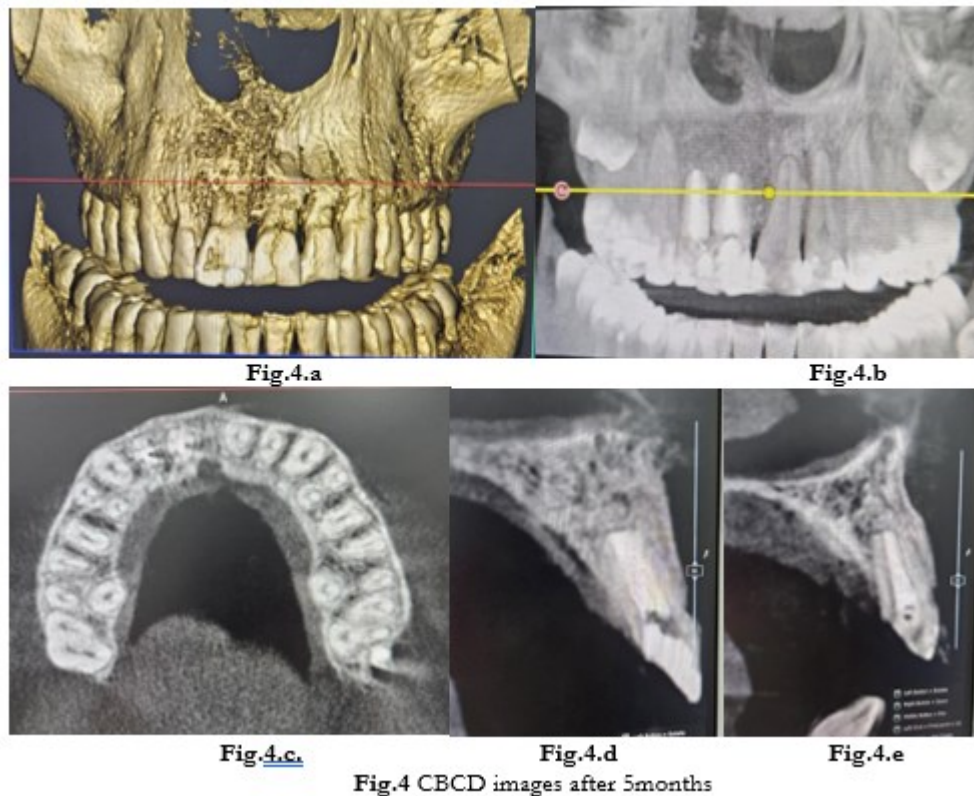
CBCT images after 5months
